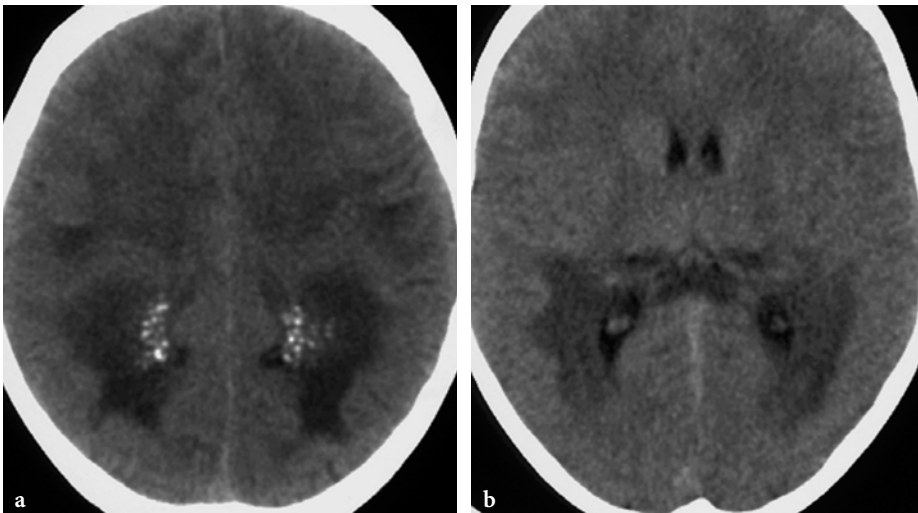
Calcifications in a 10-year-old male patient with X-linked adrenoleukodystrophy (courtesy of Dr. P. Tortori-Donati, Genoa, Italy). a, b Axial CT scans show calcifications within the hypodense cerebral white matter lesions bilaterally
